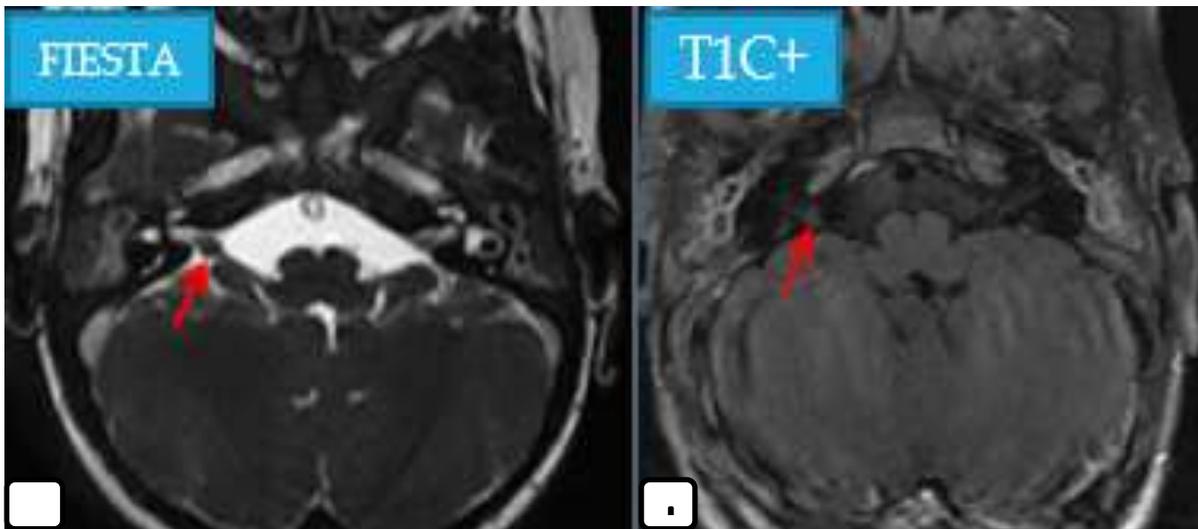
MRI in axial section in FIESTA sequence (a) and in axial section in injected T1 sequence (b): Fusiform tumefaction of the right facial nerve in its cisternal course (superiorly and anteriorly) iso-signal T2, poorly enhanced after contrast. → Schwannoma of the facial nerve
